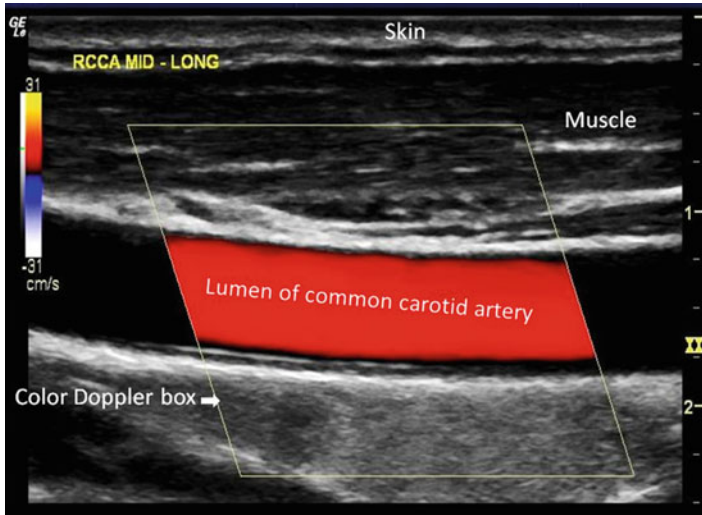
This shows a typical color Doppler display on a B-mode image with a color Doppler legend displayed on the left side of the monitor
